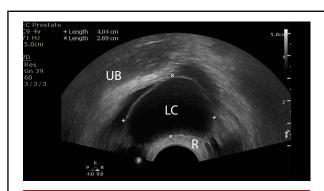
Transrectal ultrasonogram showing a left seminal vesicle cyst
